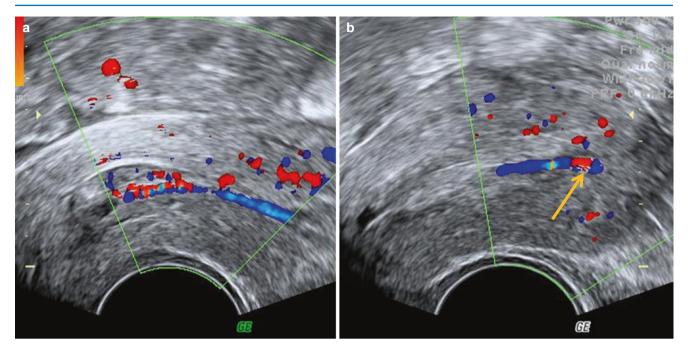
Direction and origin of flow in a case with a polyp in the cervix. (a) The flow to the polyp was seen approaching it from higher up in the endometrial cavity. (b) The origin of the feeder vessel (*arrow*) is seen at the upper end of the endometrial cavity after angulation of the probe so as to pick up Doppler signals
